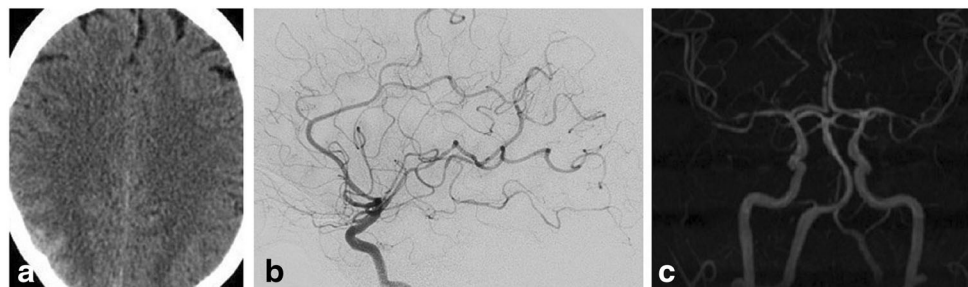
Case 1: A 54-year-old female with WFNS grade 1 SAH. a Unenhanced CT head at presentation shows a sulcal pattern of hemorrhage. b CTA reported as normal, but DSA on day 3 shows
